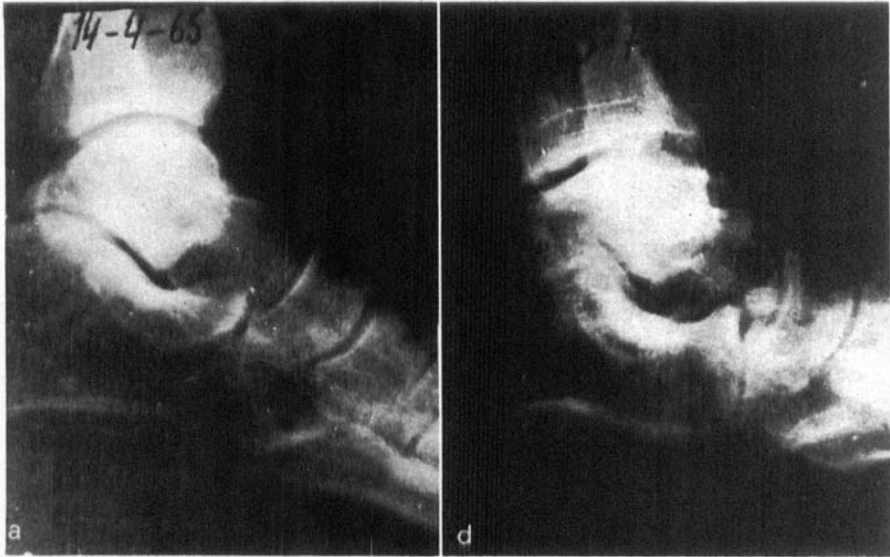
a. Lateral radiograph showing advanced replacement process of the bone of the talar body two years following avascular necrosis.
